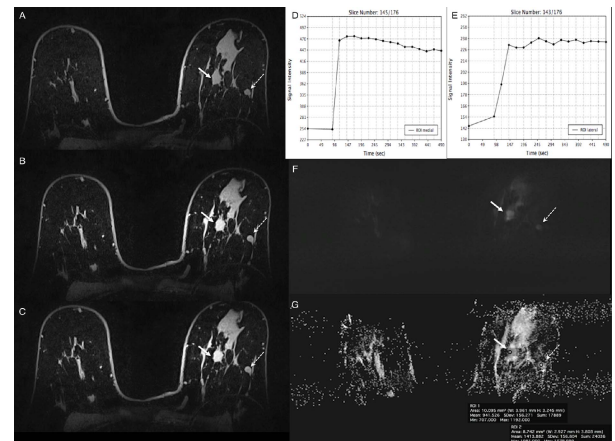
Lesion 1 IDC/G3 medially and lesion 2 fibroadenoma laterally in the left breast in a 57-year-old woman: Lesions 1: (A-C) On DCE MRI the irregular-shaped and marginated mass medially (arrow) demonstrated (D) an initial fast heterogeneous CE followed by a wash-out, had restricted (F) diffusivity and (G) decreased ADC values ( $0.941 \times 10^{-3} \text{ mm}^2/\text{s}$ ). DCE MRI and DWI were concordant and multiparametric MRI correctly classified the mass as malignant. Lesion 2: (A-C) The circumscribed, round mass lesion laterally (dashed arrow), demonstrated (E) rather homogeneous initial fast CE followed by a plateau. (F) On DWI, the lesion was bright on  $b=850$  images due to "T2-shine through," but had (G) no decreased ADC values ( $1.413 \times 10^{-3} \text{ mm}^2/\text{s}$ ). According to the BI-RADS -adapted reading algorithm, the assessment category assigned based on DCE MR imaging was overruled and multiparametric MRI correctly classified the mass as benign.
